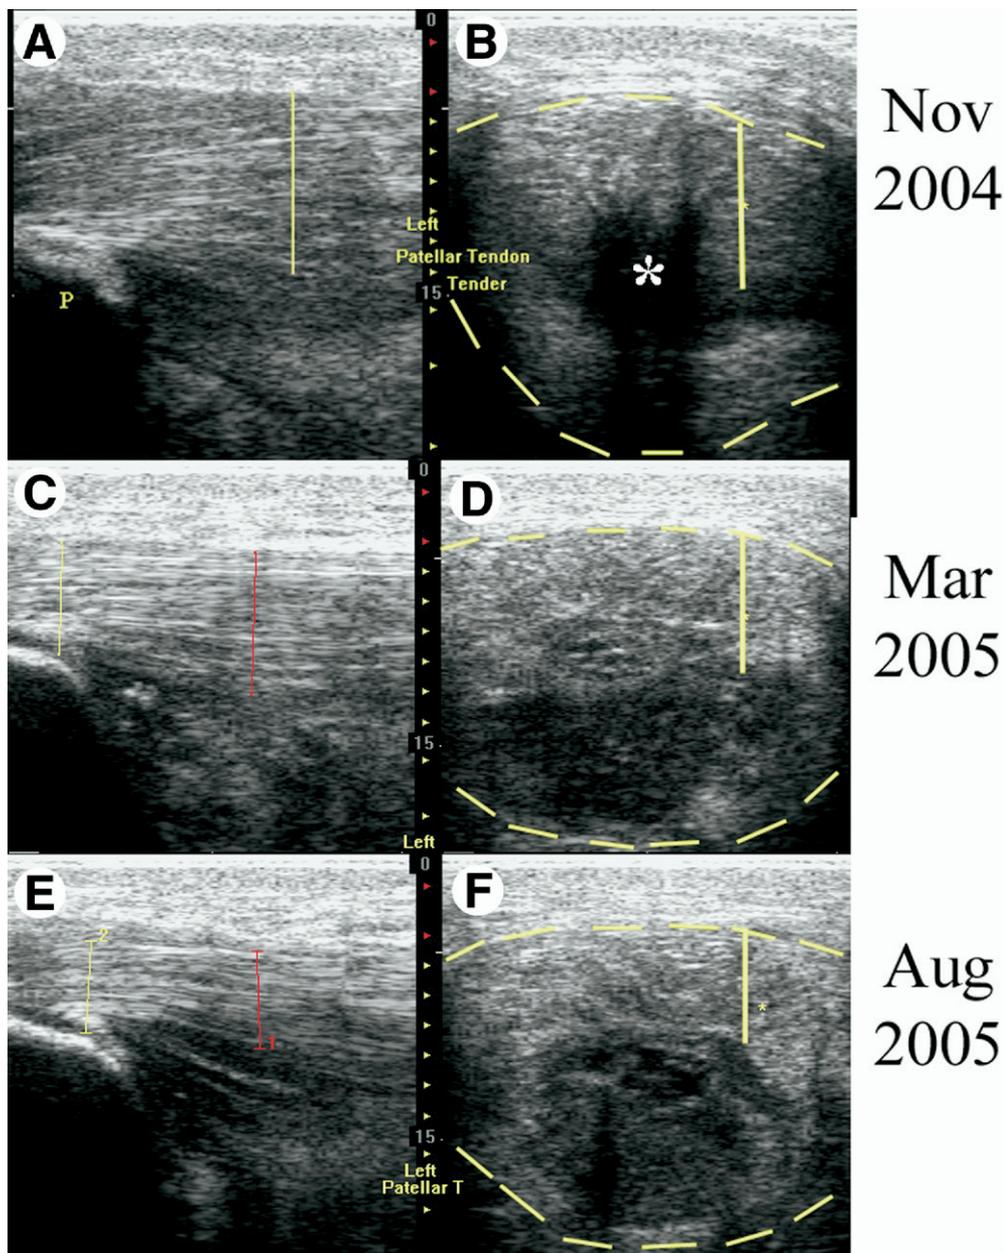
Patellar tendon ultrasound (pre- and postprolotherapy). Top row, November 2004; middle row, March 2005; bottom row, August 2005. A longitudinal view (A) shows a thickened (>10mm; normative, <4mm), hypoechoic tendon with a poor fibrillar pattern diagnostic of tendinopathy. A transverse image (B) confirms a thickened, hypoechoic tendon and reveals anechoic (black) deficit in the deep, midportion consistent with a tear (*). The images shown in C-F are at the same location after prolotherapy with dextrose and P2G, respectively. As treatment progresses, the tendon improves in tissue echogenicity, uniformity of signal, and fibrillar pattern. The anechoic tear has partially filled with new tissue (ie, it is no longer anechoic), and the main portion of the tendon is near normal thickness. Abbreviation: P, inferior pole of patella. Legend: vertical yellow lines in the right images indicates position of probe just lateral to midline for the longitudinal images on left, and the dashed yellow lines outline the tendon in transverse views on the right.
